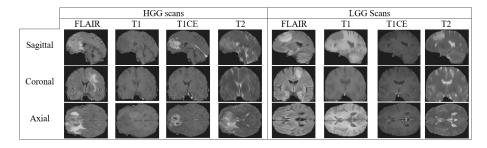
Representative LGG and HGG scans. Each column corresponds to a sequence: FLAIR, T1, T1CE, and T2. Each row corresponds to a plane: sagittal, coronal, and axial.
